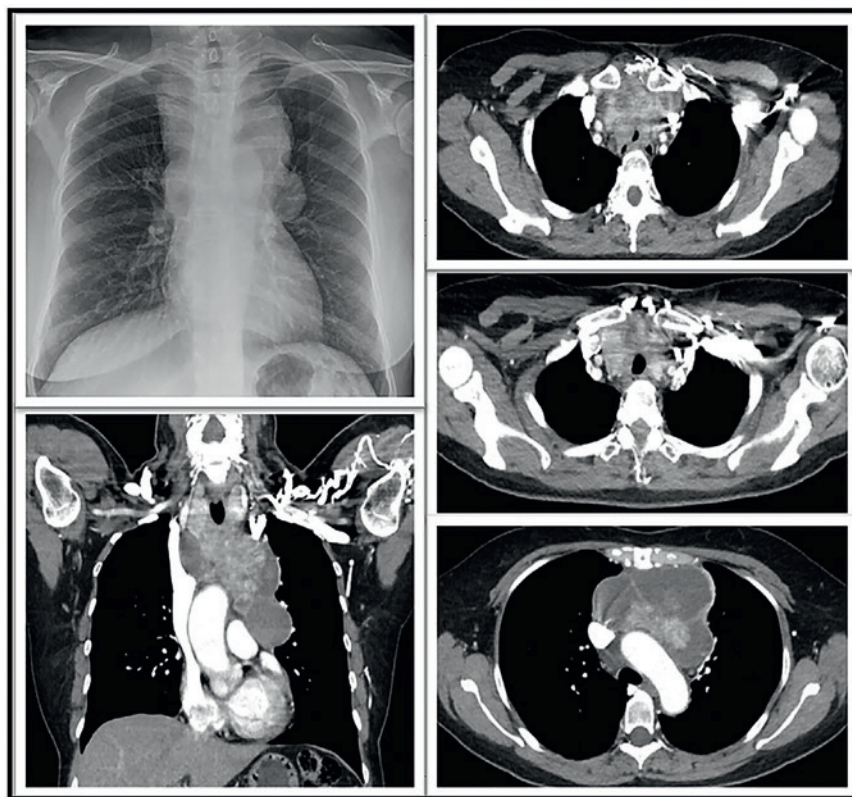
Chest X-ray and CT scan images demonstrating the mass lesion
